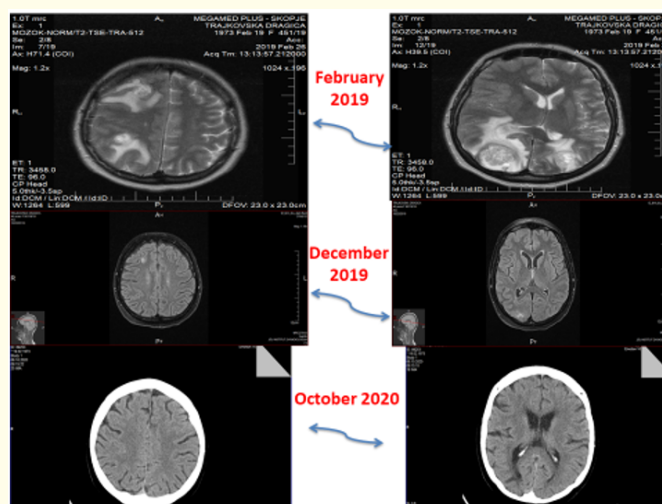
MRI et baseline for 46 years old women performed 10 months later, on December 2019 depicting the CR of all brain metastases. We had confirmation of this response 21 months later, October 2020 with brain CT.
